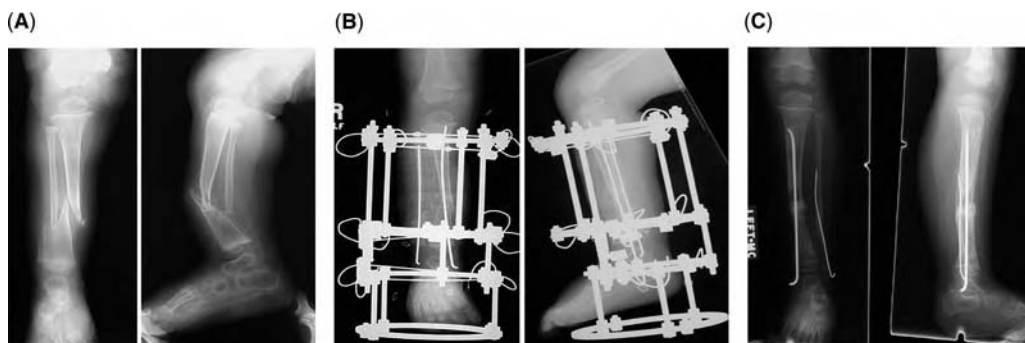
(A–C) Type I pseudarthrosis treatment. (A) Anteroposterior and lateral view radiographs of Type I congenital pseudarthrosis of the tibia in a six-month-old child. (B) Immediate postoperative radiographs showing dual rodding of tibia and fibula, bone grafting, and Ilizarov frame application. (C) Follow-up radiographs, two years postoperative showing consolidation of the pseudarthrosis and distal migration of the rod due to tibial growth.
